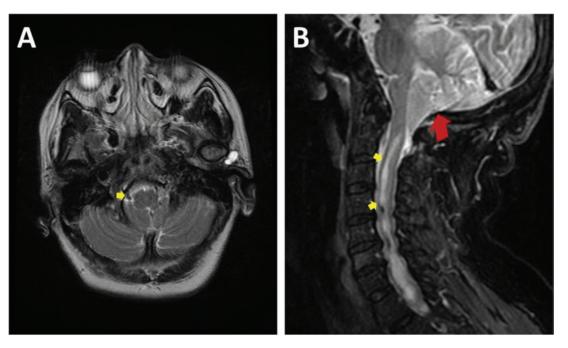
Arnold-Chiari malformation (red arrow) and cervical syringomyelia (yellow arrows). (A) Brain MRI axial T2 sequence. (B) Cervical spinal cord MRI sagittal T2 sequence.
